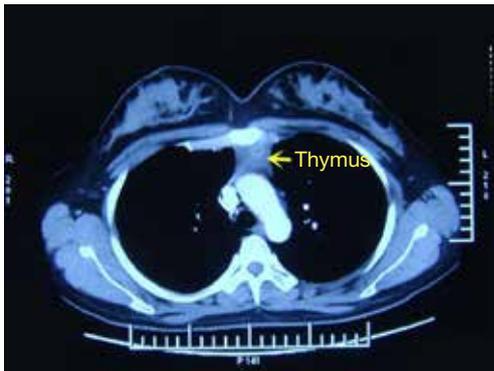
CT showed a soft tissue shadow in the anterior upper mediastinum.
